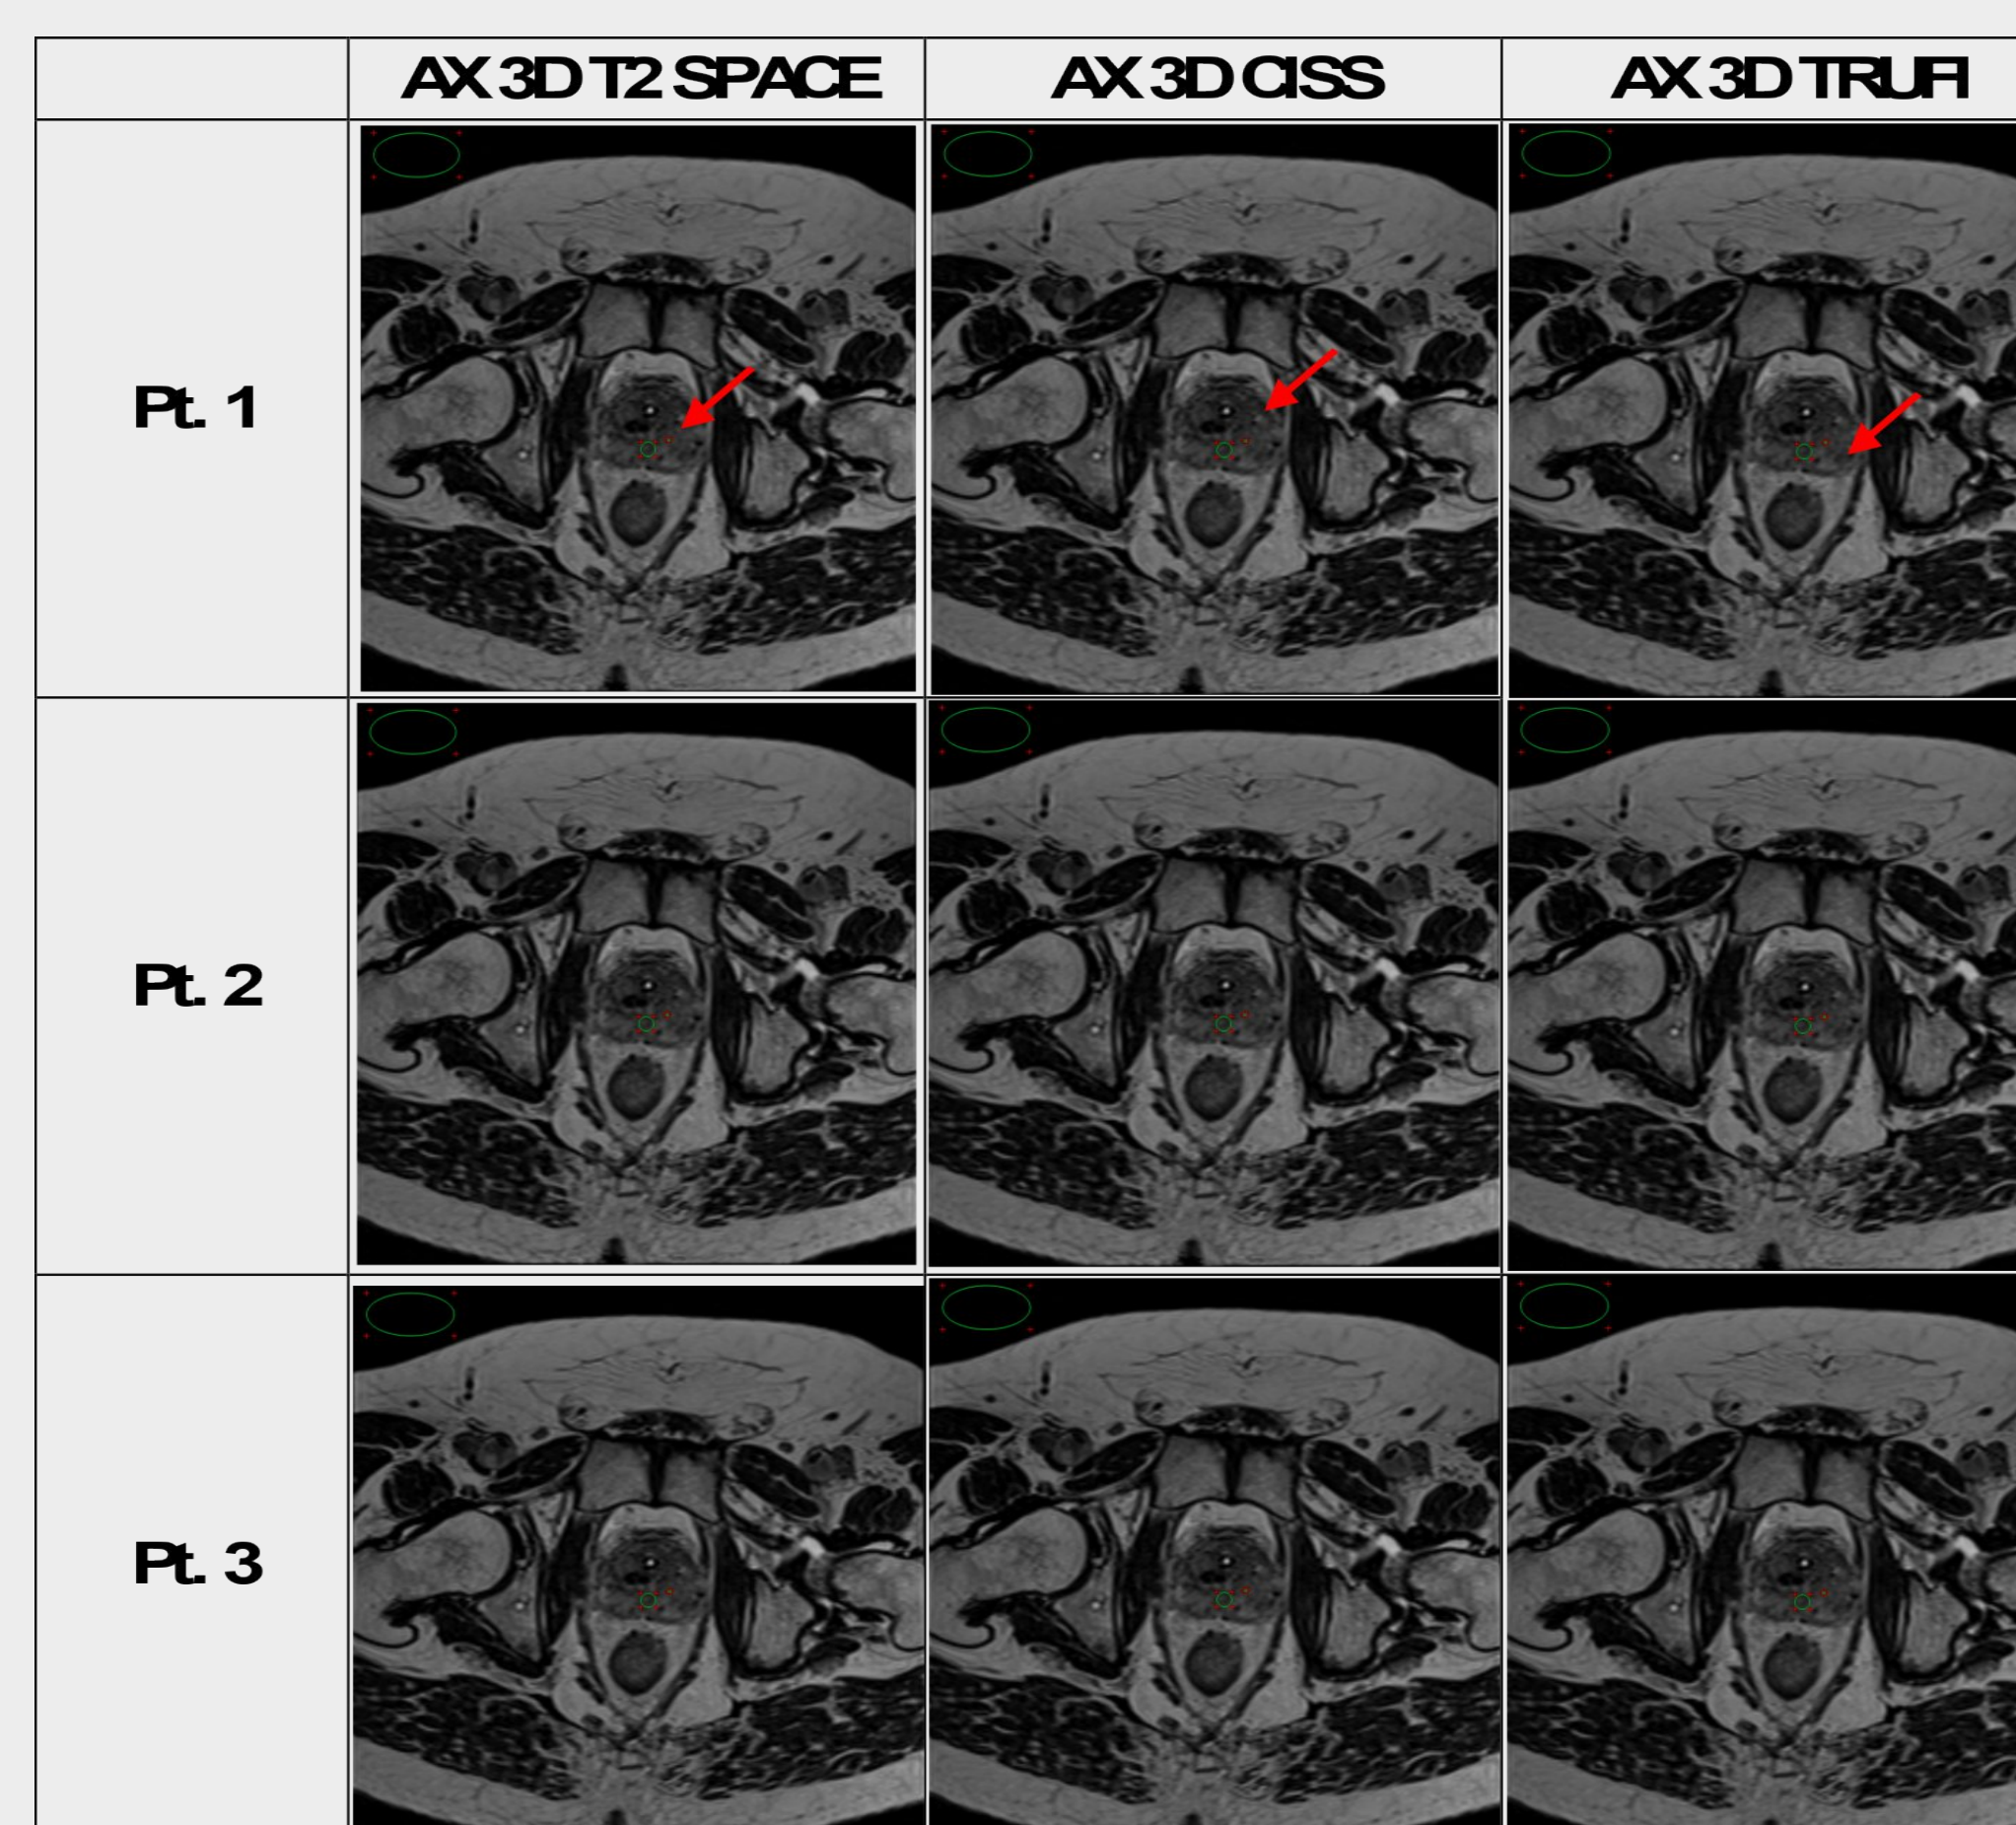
MR images of each axial 3D sequence. Green ROIs for Pt. 1 demonstrate location of signal measured in needle (red arrow) and surrounding tissue; noise measured in ROI outside patient on SPACE and in another slice on CISS and TRUFI due to small FOV.
